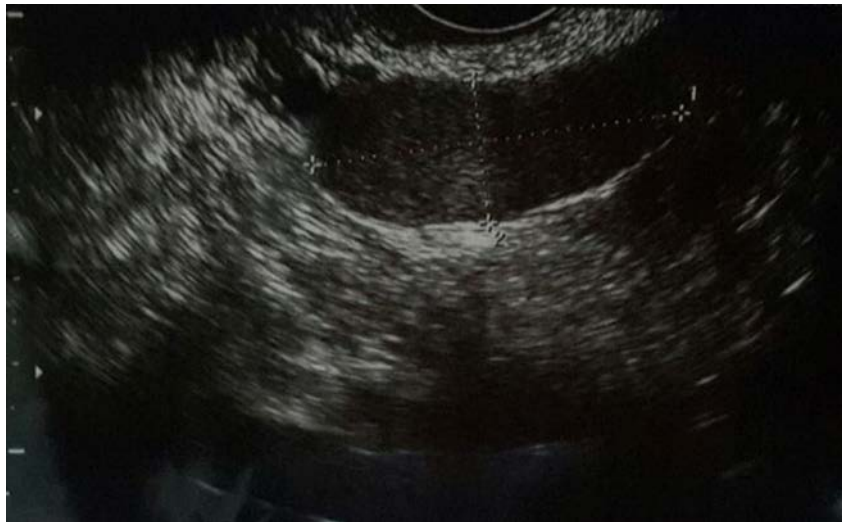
Ultrasound image demonstrating pelvic mass.
